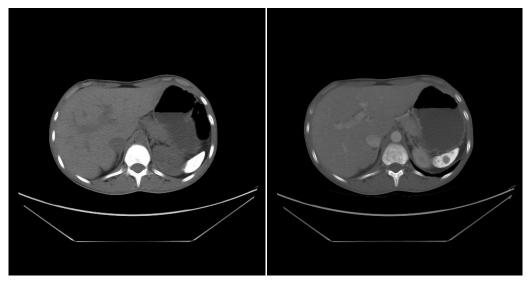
Two axial abdominal CT images of SCD patient in venous (RT) and delay (LT) phases, spleen is appear shrunken and totally calcified with small hypodense lesions.
